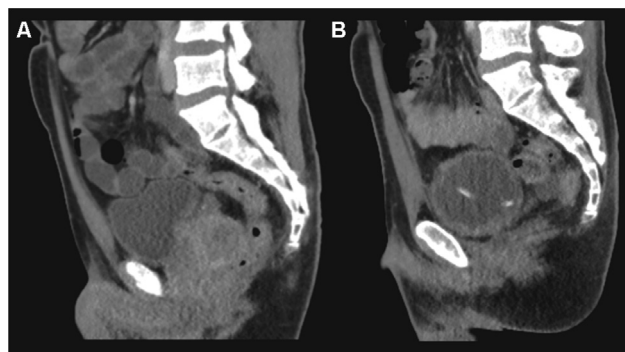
Contrast enhanced staging CT-scan of the pelvis (A) and re-staging 2 months after surgery and first cycle of adjuvant chemotherapy (B): no signs of residual disease or recurrence of the Ewing-like tumor. Urine-diversion via cystostomy-catheter after closure of the bladderneck.
